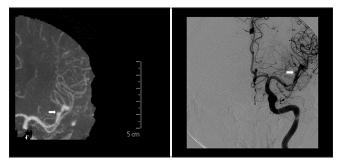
Computed tomography angiogram (left) and corresponding digital subtraction angiogram (right) images confirming the fairly long irregular fusiform dilatation (indicated by the white arrows)
